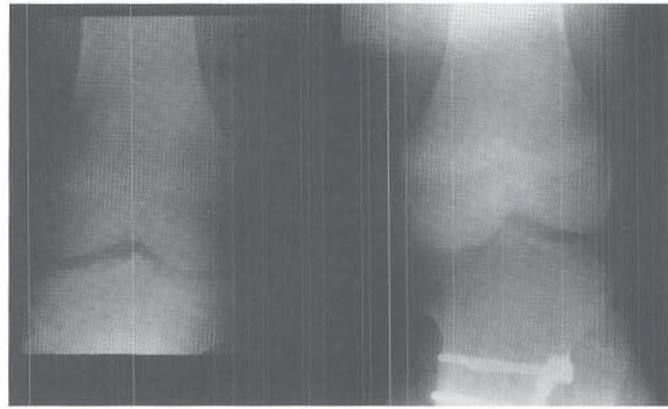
A and B, Clinical appearance of a 13-year-old, 170-kg child with adolescent tibia vara. C and D, Radiographs of right and left knees showing typical widening of the medial tibial physis and generalized epiphyseolysis across the entire proximal growth plate. Abrupt angulation at the epiphyseal metaphyseal junction is evident. E, Radiographic appearance following bilateral high tibial osteotomies with correction to neutral mechanical axis.
